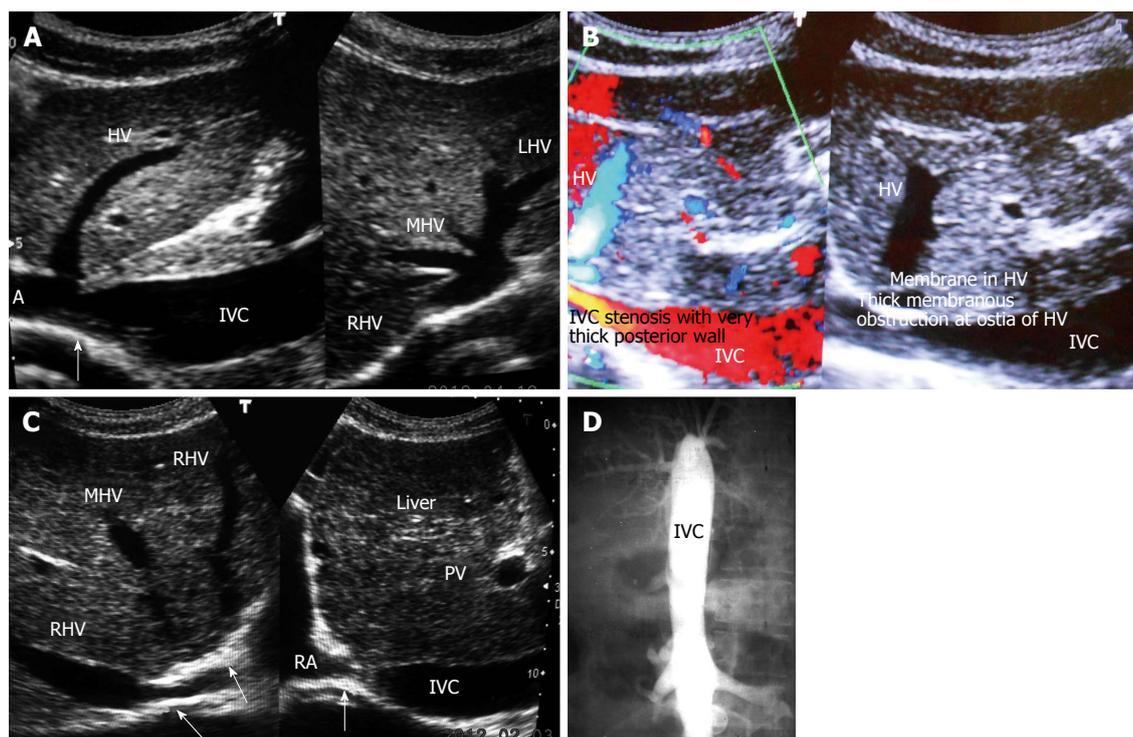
Inferior vena cava obstruction. A: Ultrasonography showing stenosis of inferior vena cava (IVC) at cavo-atrial junction. Note patent orifices hepatic vein (HV)-right HV (RHV), middle HV (MHV) and left HV (LHV); B: Color Doppler ultrasonography of a patient with liver cirrhosis showing IVC stenosis, membranes in HV; C: Ultrasonography of a patient with liver cirrhosis showing complete obstruction of IVC at cavo-atrial junction and obstruction at orifices of MHV and LHV. Note dilated hepatic veins; D: Cavogram showing complete obstruction of the IVC. PV: Portal vein; RA: Right atrium.
